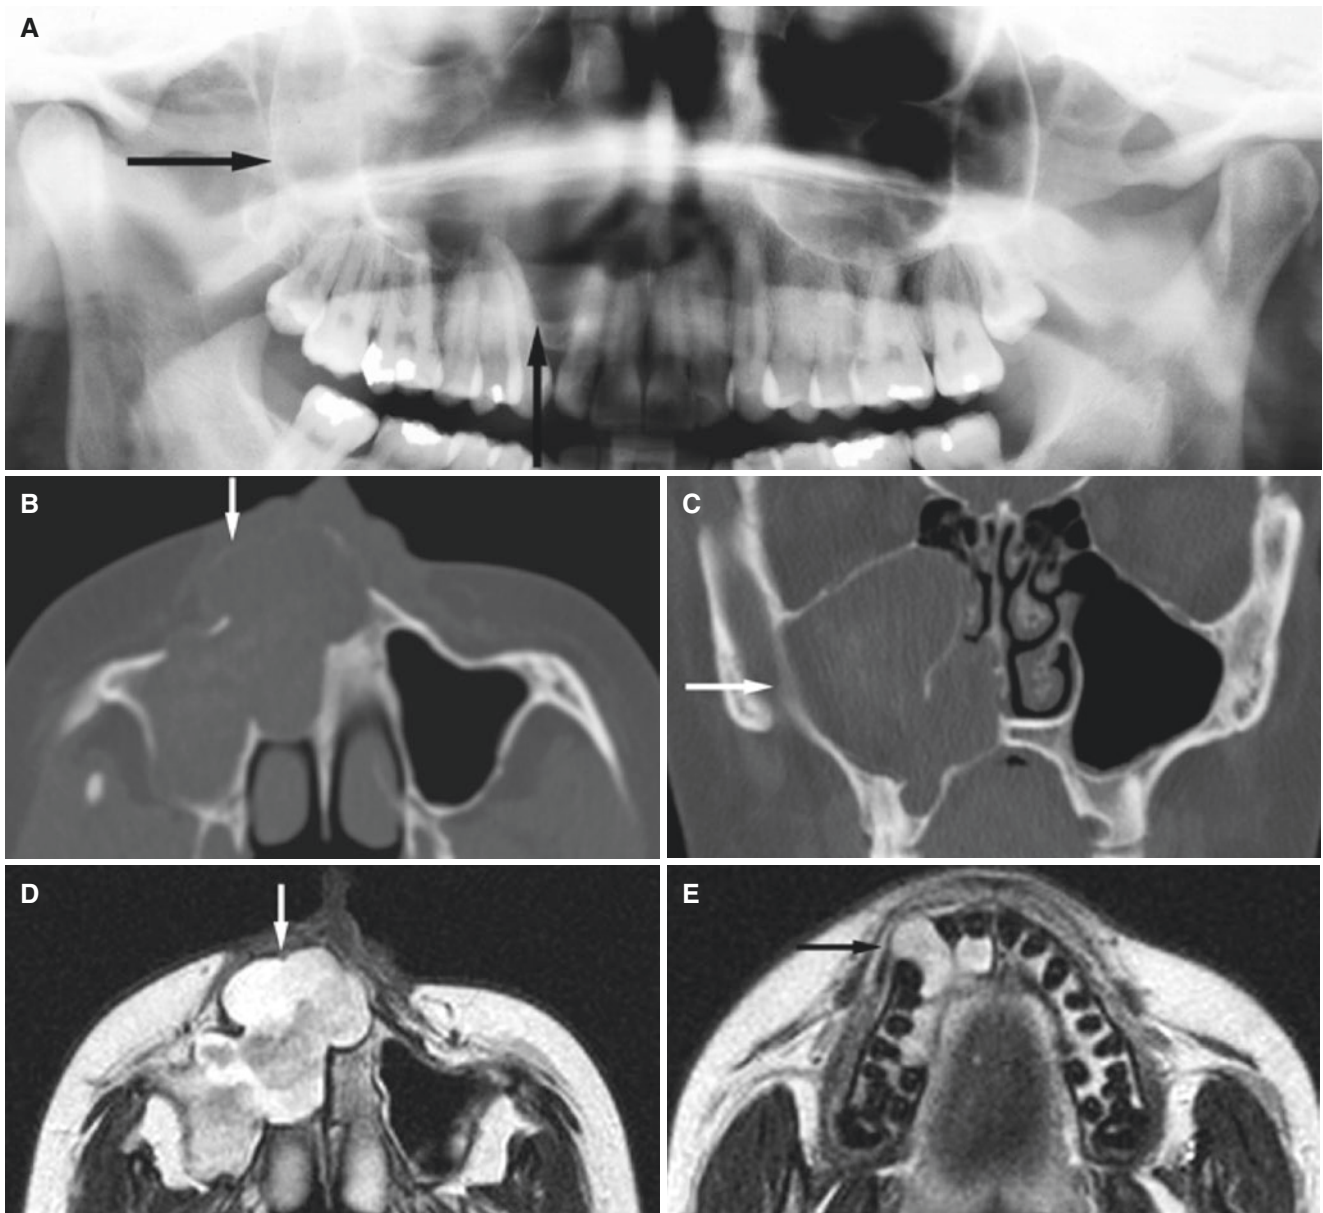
Keratocystic odontogenic tumor, maxilla; 27-year-old female, Gorlin–Goltz (basal cell nevus) syndrome, painless swelling of alveolar process. (A) Panoramic view shows radiopacity in the maxillary sinus (*arrow*) and radiolucency in the right alveolar bone and absent alveolar sinus wall (*arrow*). (B) Axial CT image shows scalloped radiolucency in the hard palate and alveolar bone with destroyed cortical outline (*arrow*). (C) Coronal CT image shows mass occupying the right maxillary sinus and nasal cavity (*arrow*), expanding orbital
